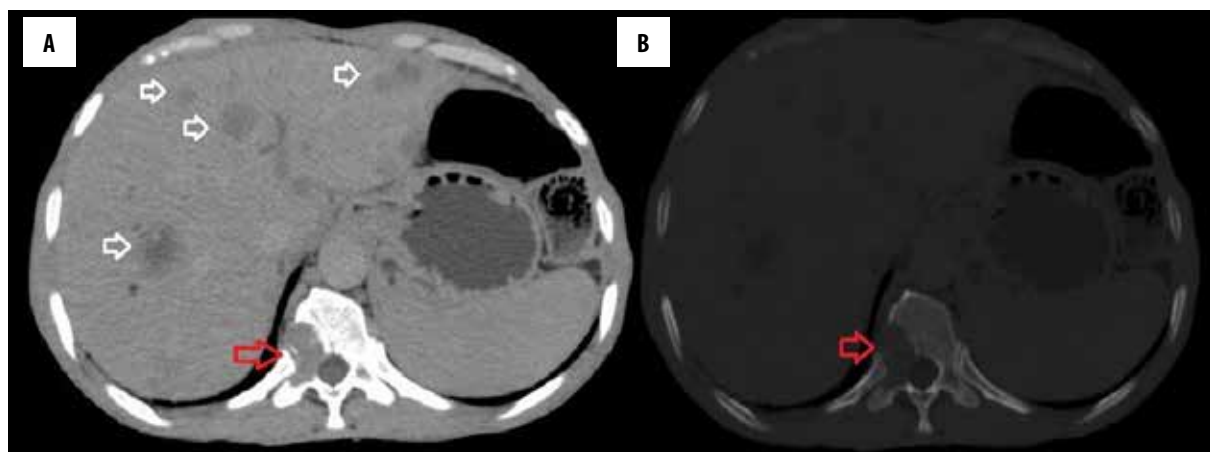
Patient 1: Axial non-contrast CT abdomen shows multiple hepatic metastases (white arrows). The red arrow points towards the skeletal metastasis to right pedicle, adjoining transverse process and posterior part of the body (soft tissue window – A; bone window – B).
